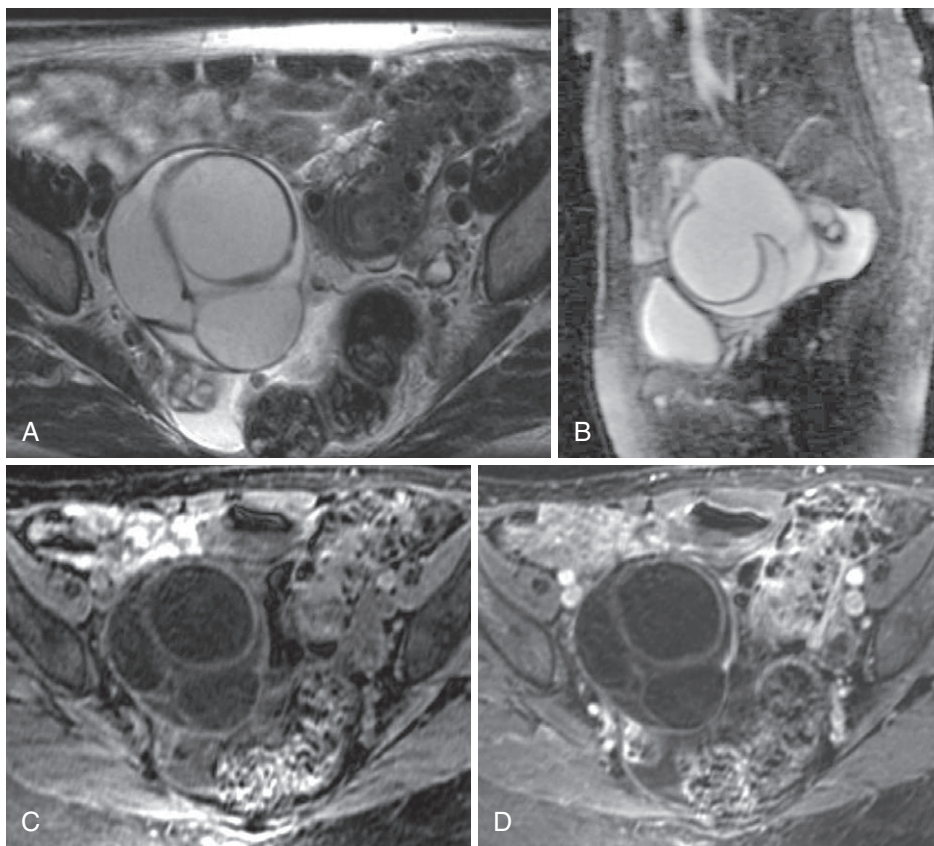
Mucinous cystadenocarcinoma. Axial T2-weighted (A) and sagittal T2-weighted fat-suppressed (B) images demonstrate a moderate-sized multiloculated cystic lesion with mildly thickened septa. T1-weighted precontrast (C) and postcontrast (D) images fail to detect any additional potential malignant features. Based on imaging findings, the likelihood of neoplasm is definite and the likelihood of malignancy is indeterminate. Surgery was recommended and a mucinous cystadenocarcinoma without evidence of invasion was resected.
